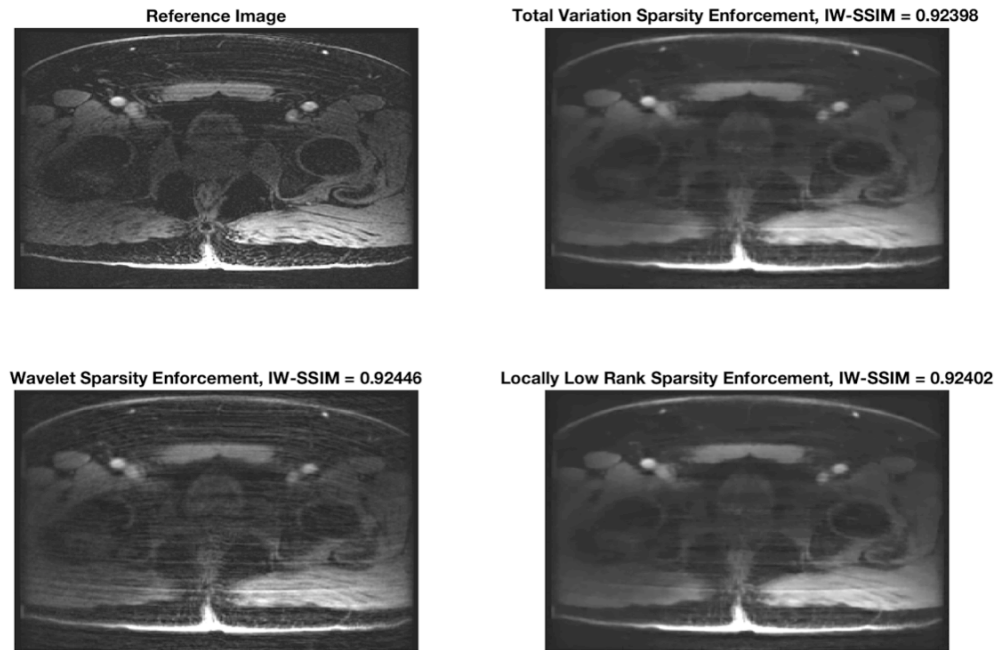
Example CS-MRI image reconstructions with similar IW-SSIM score using each of the three sparsity enforcements. Reconstruction using a wavelet sparsity enforcement showed noticeably different artifacts than TV or LLR transforms, despite having similar IW-SSIM score.
